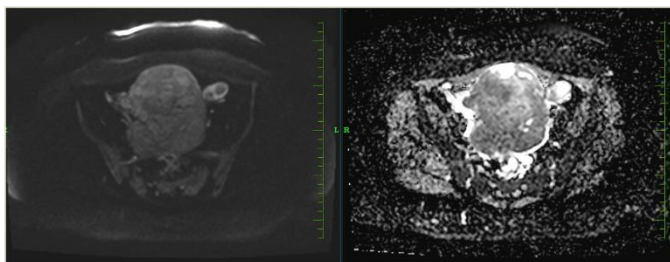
Diffusion restriction on diffuse weighted imaging (DWI) shows areas of bright signal in DWI and low signal in ADC indicating diffusion restriction, suggestive of areas of suspected malignant transformation.
